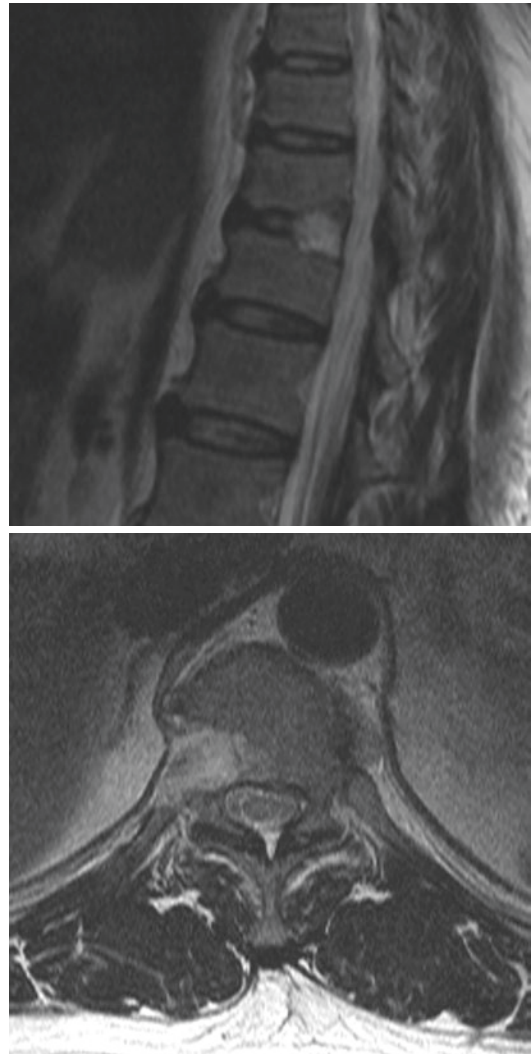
Postoperative MR images
